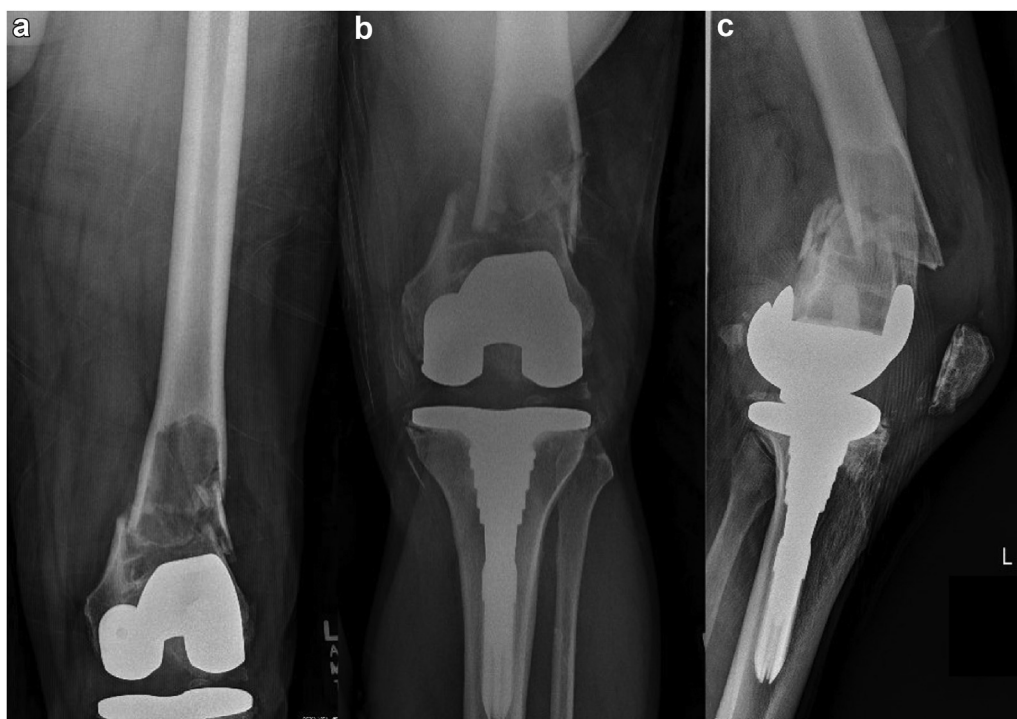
(a and b) Anteroposterior (AP) and (c) lateral radiographs of the left femur demonstrating a comminuted, periprosthetic supracondylar fracture about a well-fixed, cemented posterior-stabilized femoral component of a total knee arthroplasty through a massive osteolytic lesion measuring 5×9 cm.
